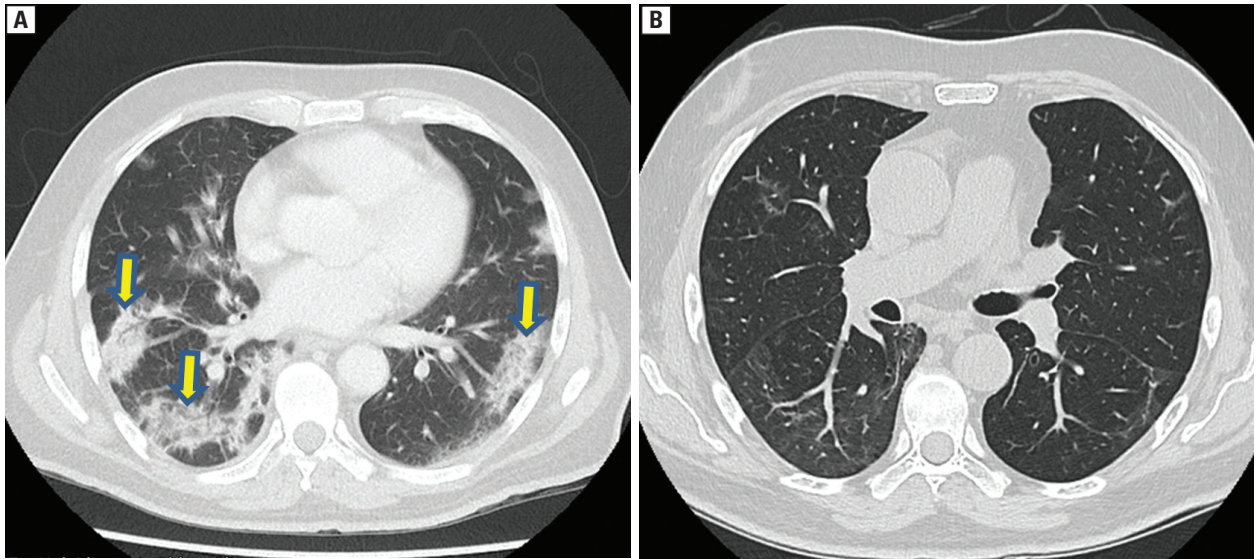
HRCT of the chest showing A. peripheral patchy areas ground glass opacities (GGOs) with consolidation consistent with an OP (organizing pneumonia) pattern (yellow arrow pointing towards peripheral patchy GGOs); and B. near complete resolution of peripheral patchy consolidation after initiation of corticosteroids
